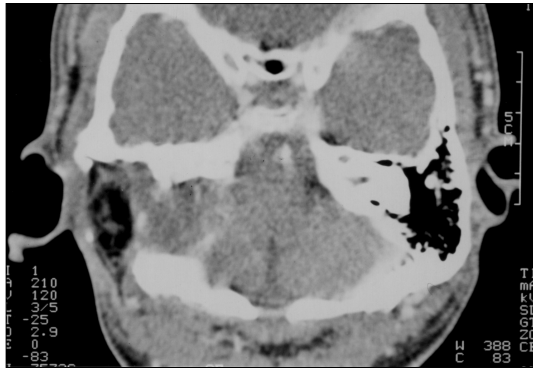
Temporal bone CT scan 19 months after operation. There is no definitive evidence of recurrence except several focal areas of inflammation.
